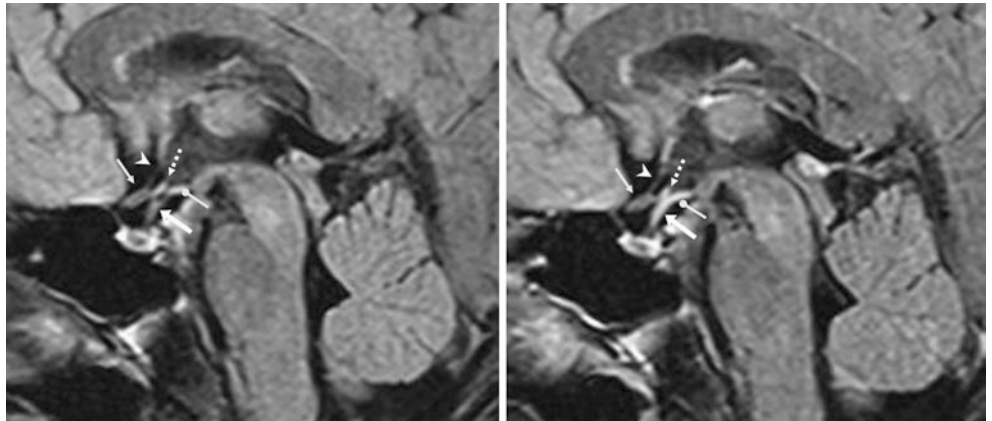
A 22-year-old male patient with 3 T MRI sagittal pre- (*left*) and postcontrast (*right*) T1WIs demonstrating normal enhancement of the infundibulum (*arrows*) relative to the nonenhancing optic chiasm (*thin arrows*). Also, note the enhancement of the median eminence (*dashed arrows*) and of the tuber cinereum (*circle tip arrows*)
